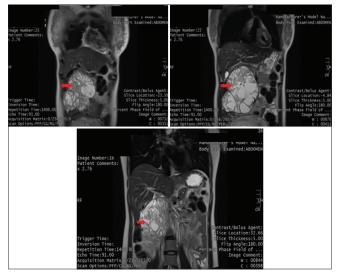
Whole abdominal Magnetic Resonance IMaging (MRI) at 13 weeks age of gestation. A large lobulated complex mass (red arrow) is seen in the right upper abdomen measuring up to 12.7 cm × 10.9 cm × 8.7 cm. It appears mostly cystic with interspersed solid components appearing T1/T2 hypointense, with patchy areas of restricted water diffusion and magnetic susceptibility artifacts
